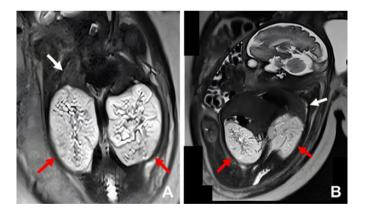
Appearance of the kidneys as seen through fetal magnetic resonance imaging. Note the similarity to the findings observed in the ultrasound examination. The red arrows indicate the kidneys, and the white arrows indicate the lungs, which appear hypoplastic based on their size (A and B).
